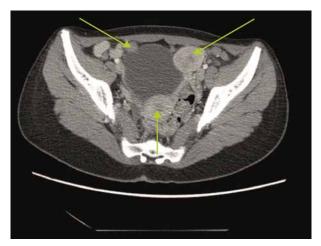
Computed tomography scan at presentation: numerous lesions in pelvis, the largest to the left of the bladder, with a contrast enhancement similar to the spleen density
